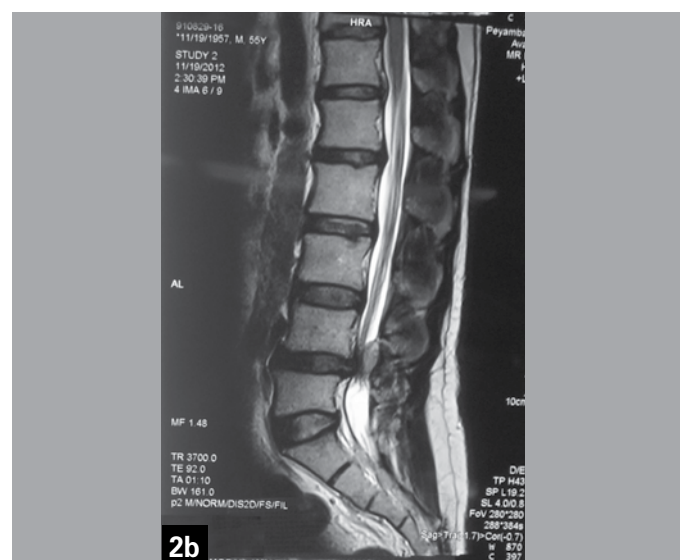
Sagittal T2-weighted image showing the same mass with isointensity.
